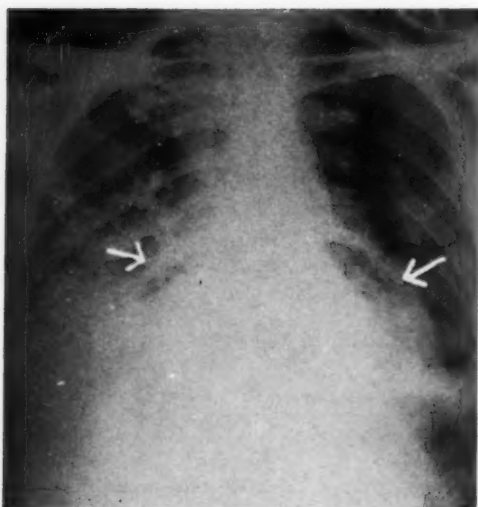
Case II. Bedside roentgenogram showing pneumopericardium. Arrows point to the parietal pericardium. There is bilateral bronchopneumonia.
